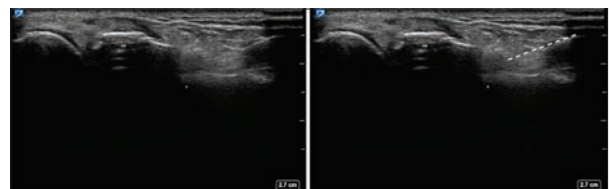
Point-of-care ultrasound visualisation of a needle entering the distal radius fracture haematoma (left image). Dotted line representation of needle path (right image). DR: Distal radius, C: Cortex.
